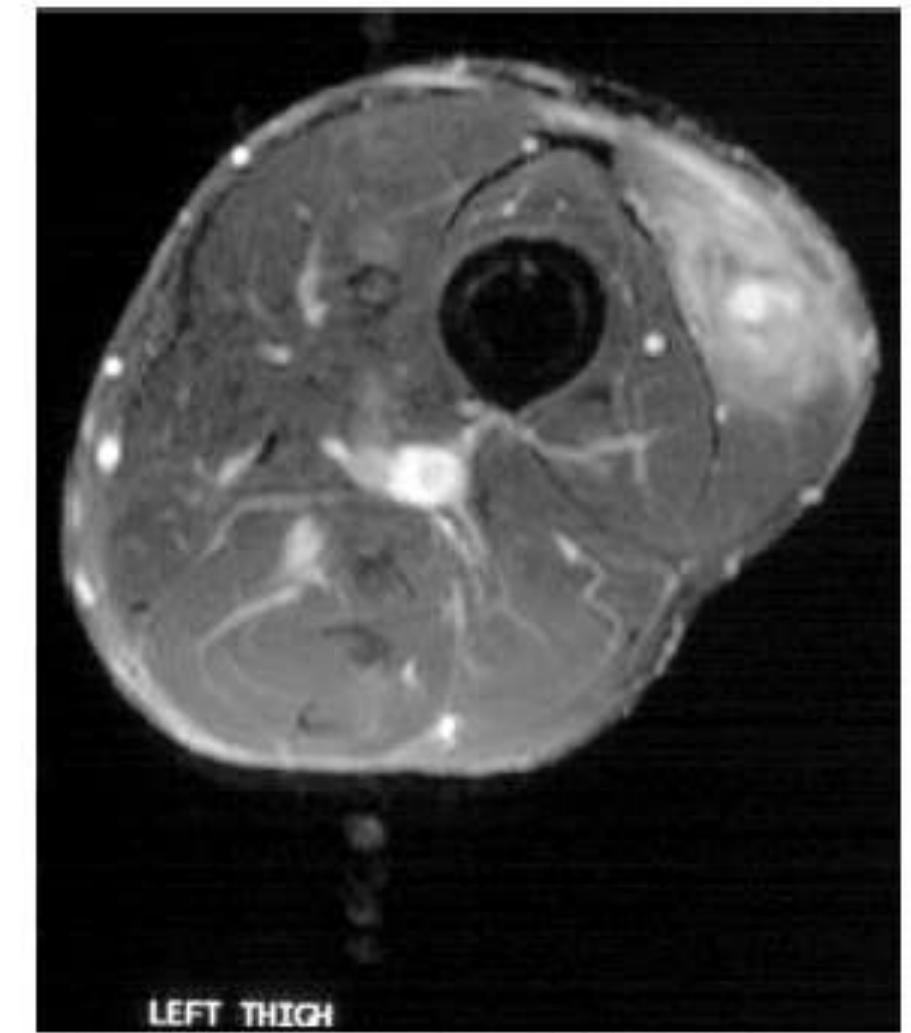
Magnetic resonance image of thigh with *Gnathostoma* sp. larva. (Reprinted from reference 25.)
